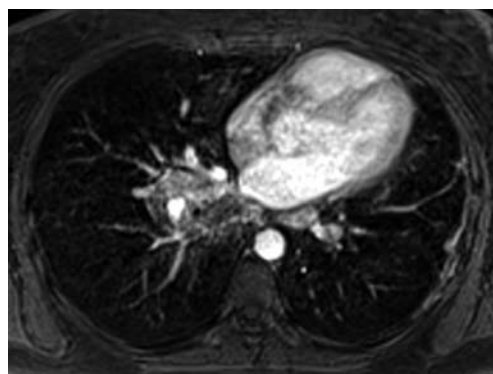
Chest magnetic resonance imaging performed 2 months after treatment showing enlarged right hilar and mediastinal mass and narrower right lower bronchus
